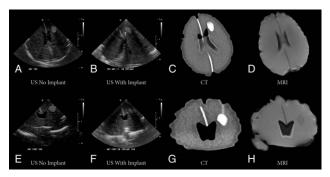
Radiographic results are presented. A 1 to 5 MHz Philips S5-1 sector array transducer on a Philips EPIQ 7G ultrasound system successfully generated images through a sonolucent, clear-colored cranial implant (made of PMMA) (B and F) which are similar to images obtained with ultrasound in the absence of a skull implant (A and E) and axial images obtained with CT and MRI (C, D, G and H). Edge shadowing was present during ultrasound through and in the absence of the implant. The interference and shadowing were greater during TCU through the implant but with transducer manipulation, this artifact could be strategically positioned away from the region of interest.
